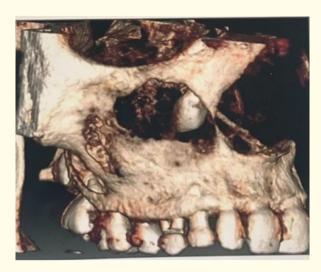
CBCT (cone beam CT assessment) mixed dentition was reported and in maxillary arch lesion observed was approximately $35 \times 40 \text{ mm}$ in size.
